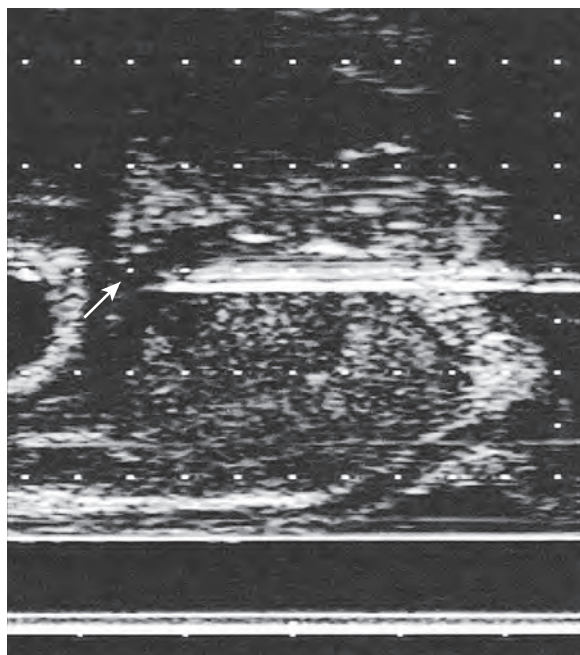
Parasagittal ultrasound image of the prostate. The arrow demonstrates that the needle depth goes to the prostatic capsule before deployment of the radioactive seeds.
